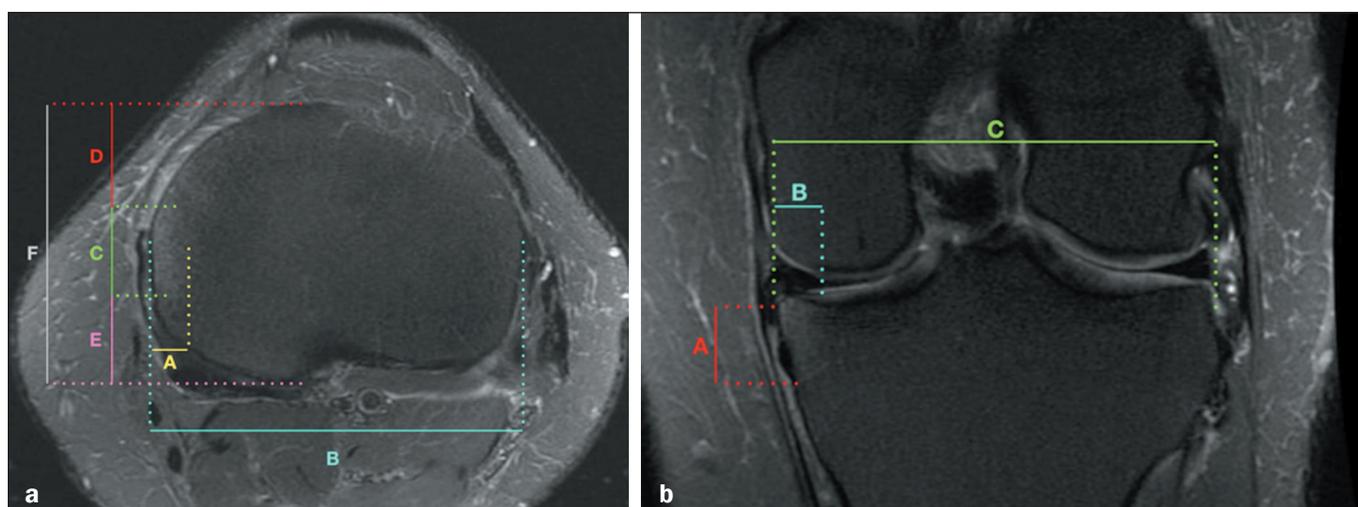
T2-weighted MRI with fat saturation, showing an example of bone edema measurements. a: In the axial plane, measurements were made of the largest mediolateral diameter of the edema (A) and tibia (B), together with the anteroposterior measurements of the edema (C), the distance from the edema to the most anterior cortex of the tibia (D), the distance from the edema to the most posterior cortex of the tibia (E), and the greatest distance between the anterior and posterior cortex of the tibia (F). b: In the coronal plane, craniocaudal and mediolateral measurements of the edema were made (A and B, respectively), as was a measurement of the mediolateral length of the tibial plateau (C).
